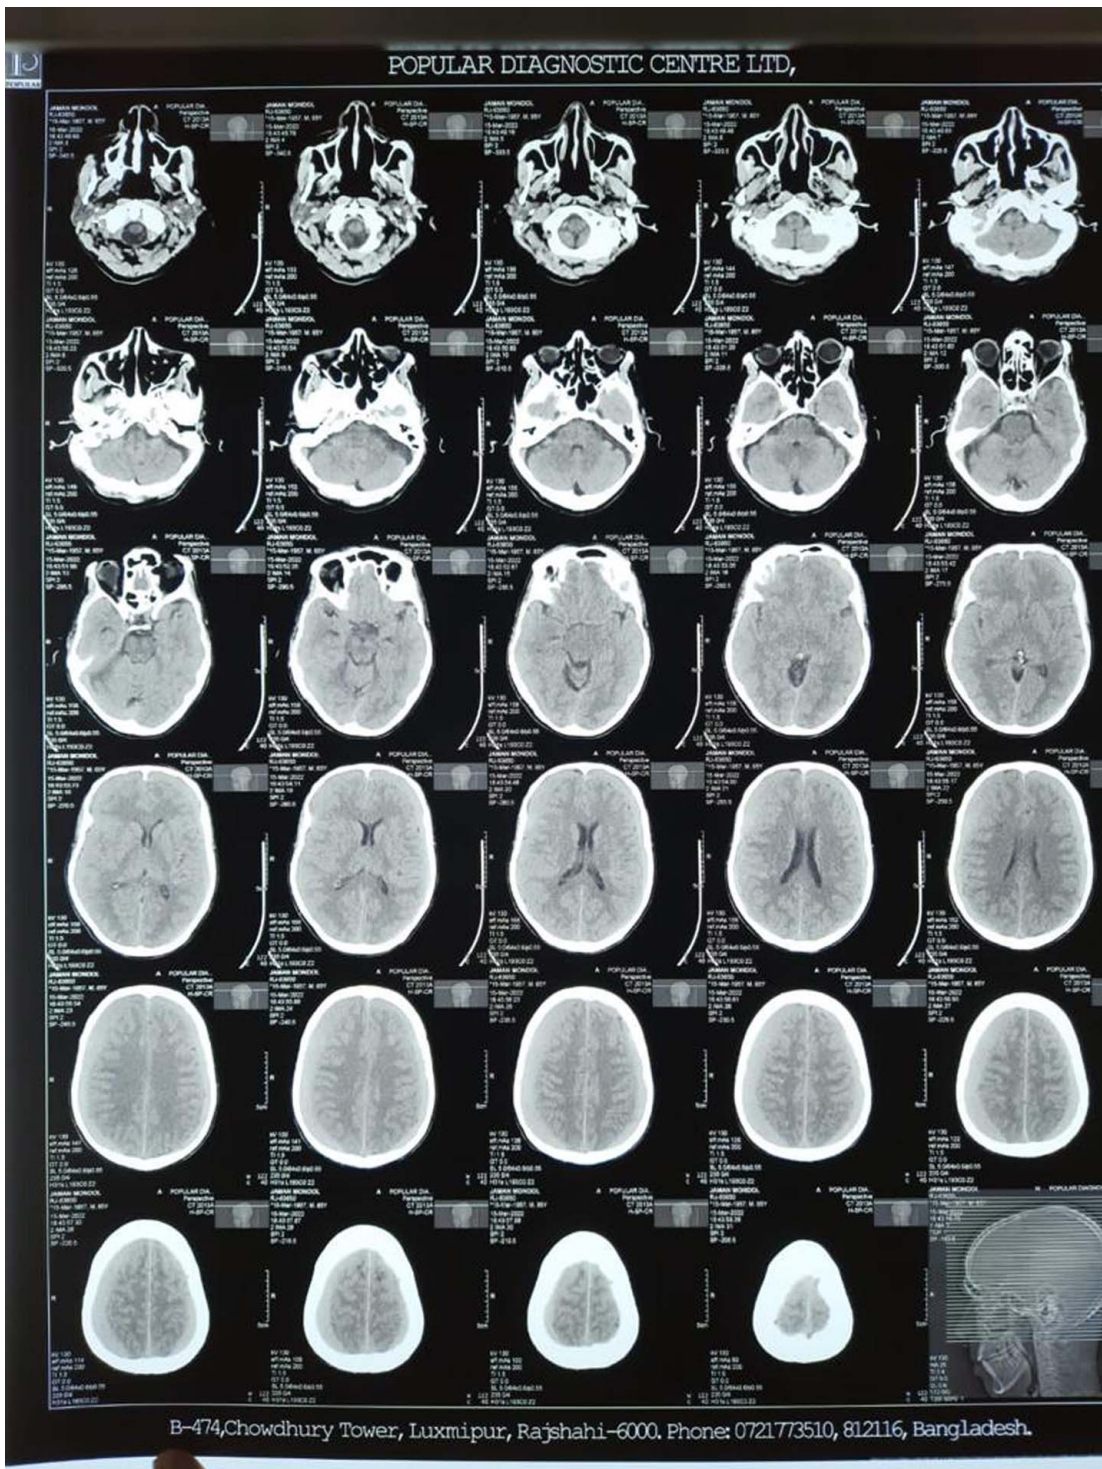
Initial computed tomography Scan of brain showing bilateral subdural haematoma at both fronto-parietal convexity that is more on right side. (Just after the head injury).
